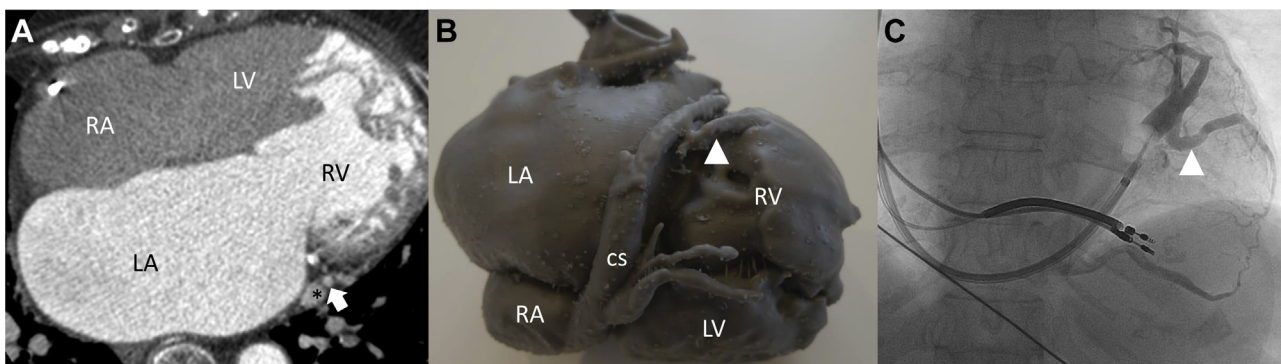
Three-dimensional (3D) printed model of congenitally corrected transposition of the great arteries for preoperative planning in cardiac resynchronization therapy (CRT) device implantation. A: Computed tomography imaging of the coronary sinus (CS). The arrow indicates the target branch of the CS. The asterisk indicates the main CS body. B: 3D printed model of the heart. The white arrowhead indicates the target branch. C: Venogram during CRT implant procedure. The white arrowhead indicates the target branch. LA = left atrium; LV = morphologic left ventricle; RA = right atrium; RV = morphologic right ventricle.
